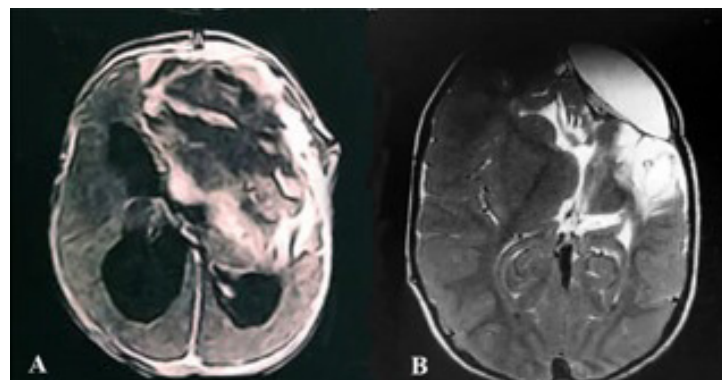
(A) Postoperative MRI showing postoperative hydrocephalus. (B) The last MRI follow-up, axial T2 image, 2 years postoperatively, revealed no tumor residue or recurrence.
